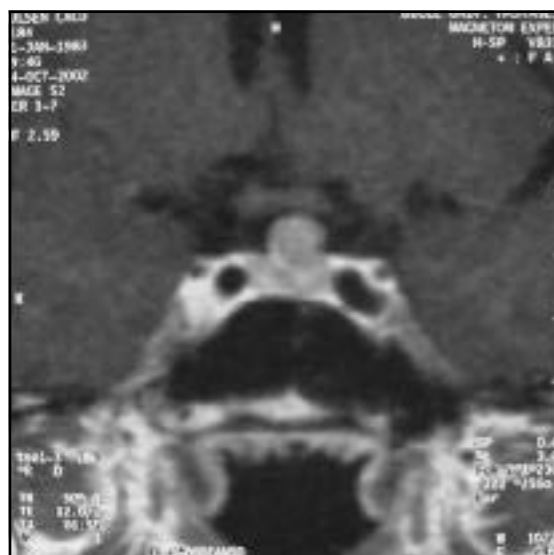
Micro adenoma in MRI of pituitary of the patient in frontal view.
